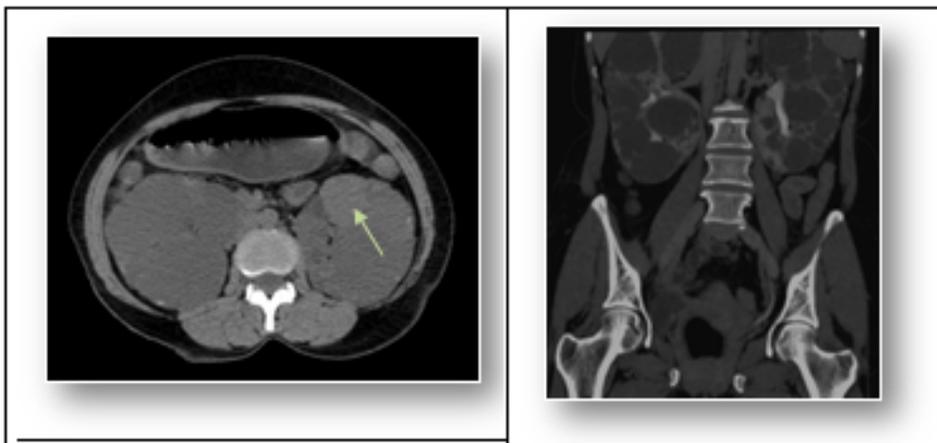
Axial unenhanced image from a CT Urography study showing enlarged kidneys with multiple cysts within. One of the cysts shows hyperdense contents on plain scan s/o hemorrhage (arrow). Coronal MIP reconstructed image of pyelographic phase shows thinned out and stretched pelvicalyceal system giving a “spider leg” appearance. A case of Autosomal Dominant Polycystic Kidney Disease .
